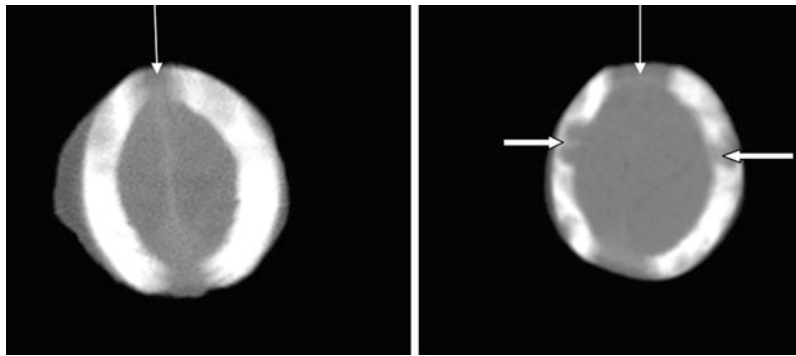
Bone window of computerized tomography (CT) scans of the head show progressive widening of the sutures (*thin arrows*) and calvarial bone destruction (*thick arrows*). *Left*: first day of life. *Right*: age 2 months
